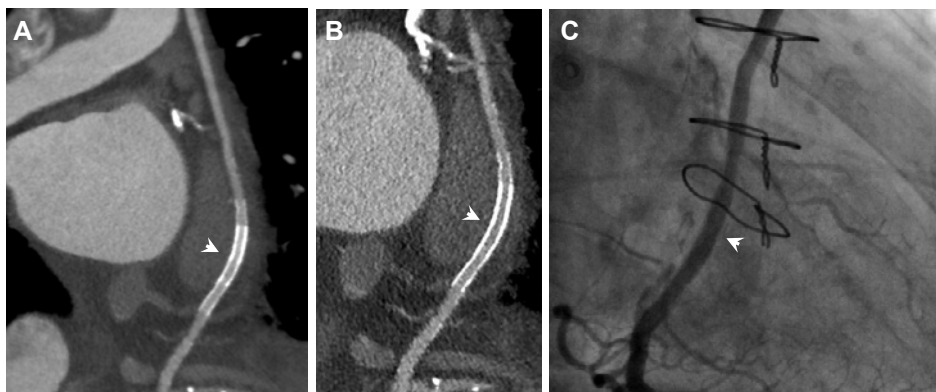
320-row CTA demonstrates in-stent restenosis in a drug-eluting stent (Endeavor, 2.75 mm x 24 mm) placed in the proximal LAD of a 62 year-old male patient. A curved multiplanar reconstruction in panel A shows significant in-stent restenosis (arrowhead). In panel B, an enlarged curved multiplanar reconstruction is shown. In the upper right-hand corner three transverse sections of the stent and distal stent edge are shown, revealing low-attenuating neointimal hyperplasia corresponding to a severe lesion in the distal stent lumen (arrow b) and a subtotal stenosis at the distal stent-edge (arrow c). Panel C shows an invasive coronary angiogram confirming both findings (arrow and arrowhead).
